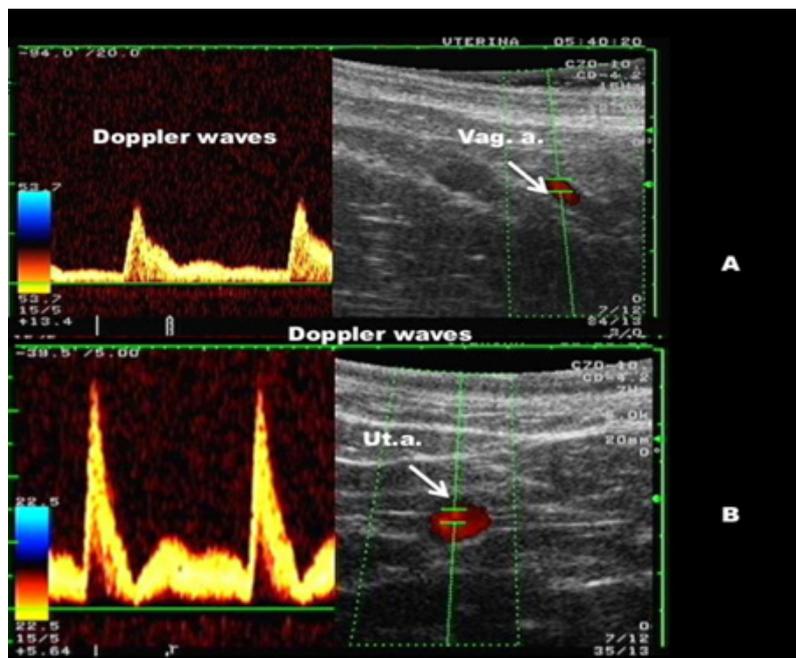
Time-dependent changes in frequency shift of an artery for the duration of cardiac cycles detected by Doppler spectral mode.
